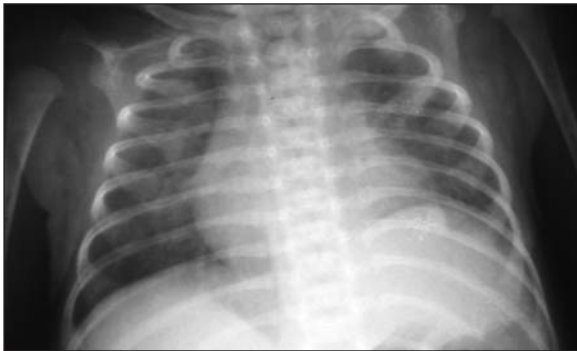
Follow-up chest X-ray demonstrating normal position of left hemidiaphragm.
